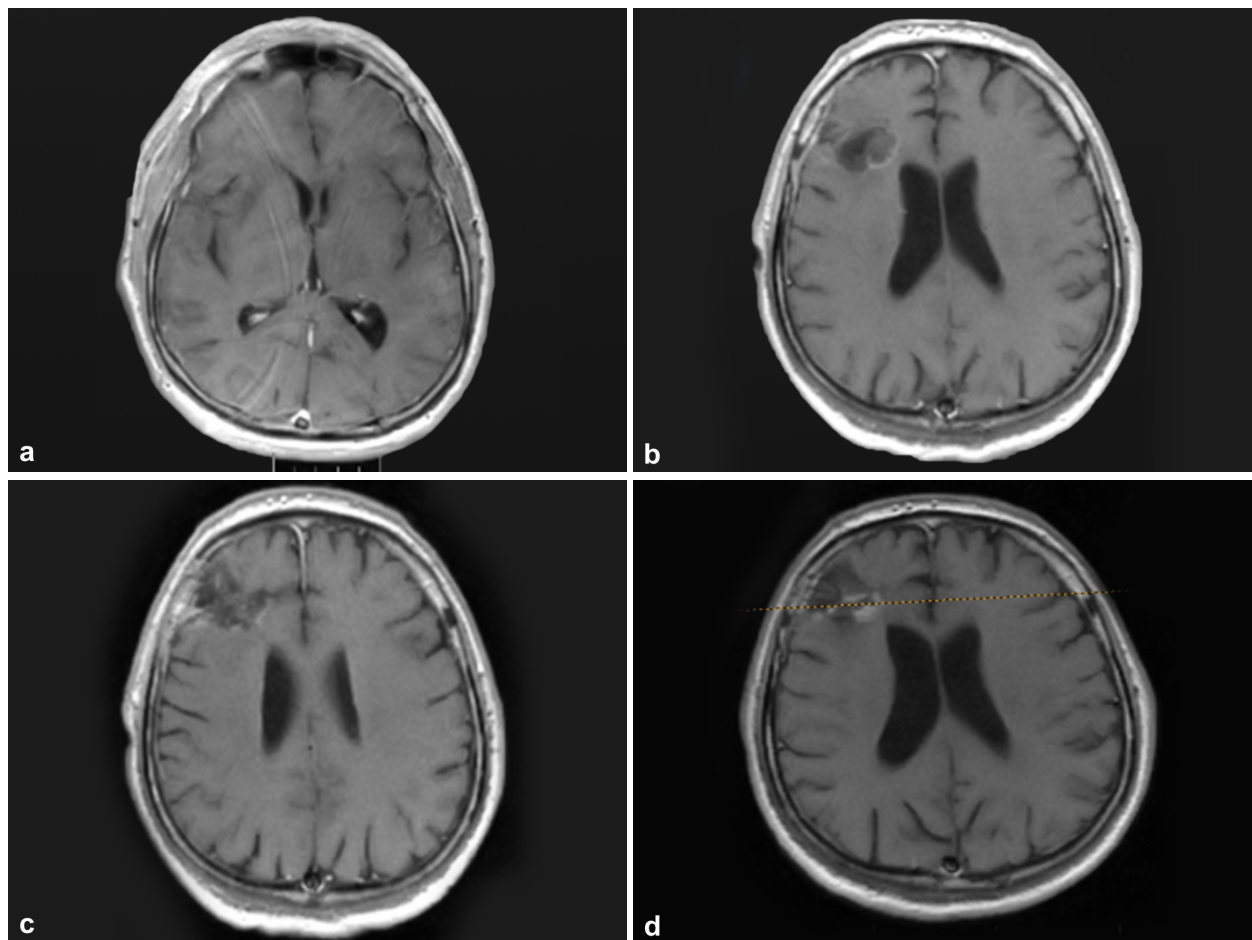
(a) Postoperative axial T1 with gadolinium MRI scan demonstrated the complete resection of tumor; (b) Brain MRI scan after three months did not reveal any recurrent tumor on axial T1 with gadolinium; (c and d) Brain MR images after 10 months from the first intervention showed a small mass with heterogeneous peripheral enhancement on T1 axial scans.
